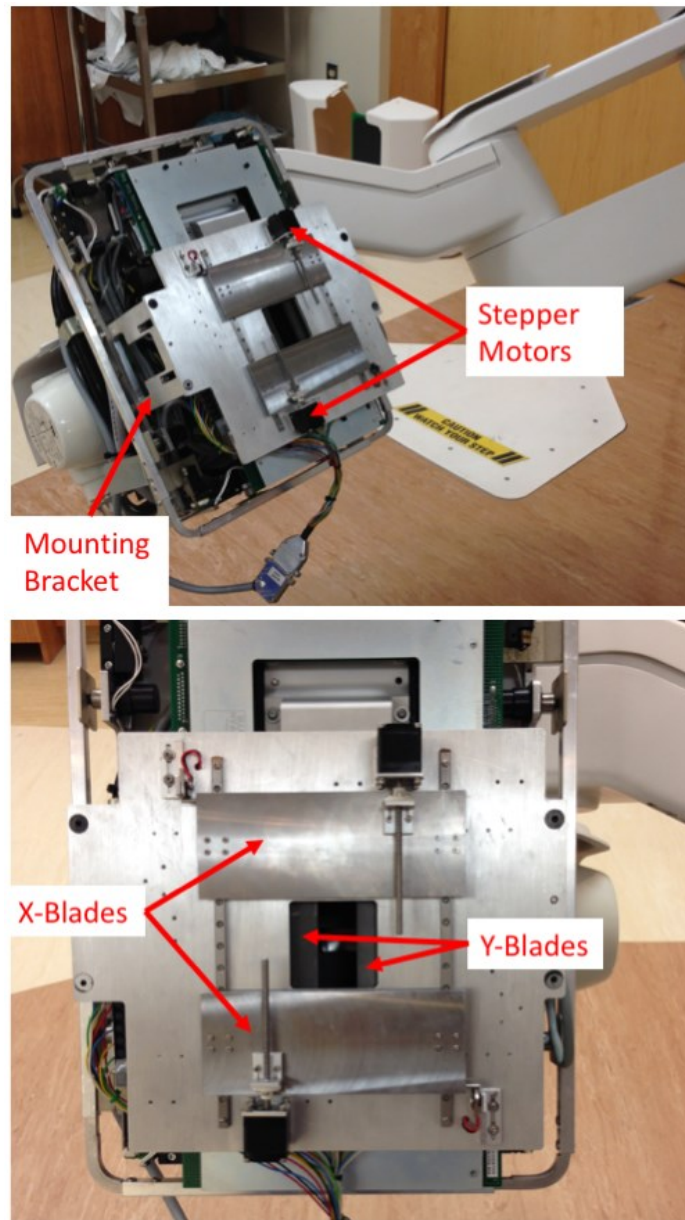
(Top) Robotic blade collimator attached to the x-ray tube on a Varian TrueBeam STx unit.
